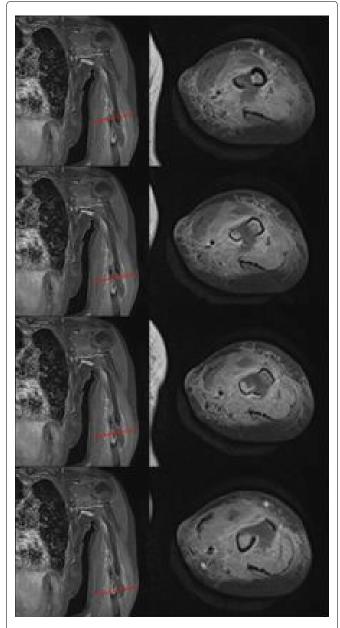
Pre-Op Magnetic Resonance Imaging (T1 weighted with contrast Coronal and Axial).
